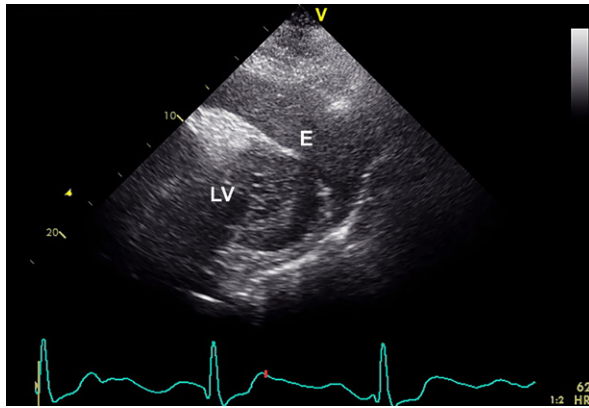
Transthoracic echocardiogram (subcostal view) shows a large anterior pericardial effusion (E) and the left ventricle (LV).
